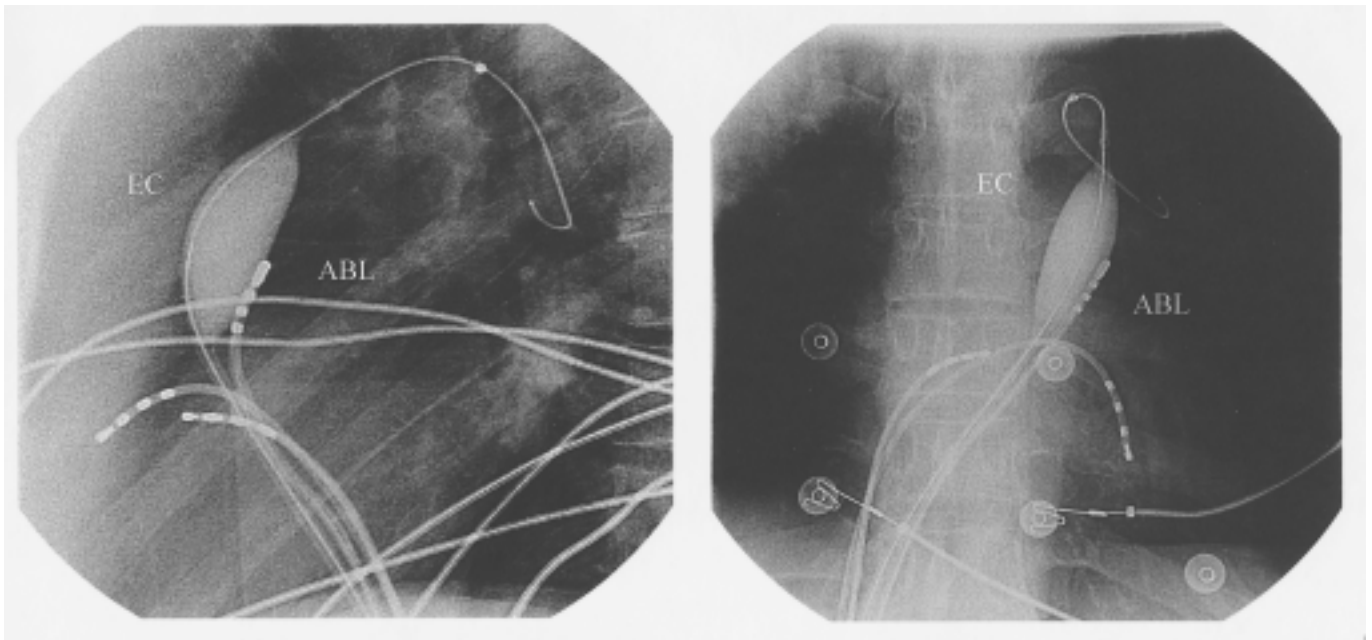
Right Panel. Anteroposterior view, and Left Panel. Lateral view. X-rays of the patient with ARVD and symptomatic ventricular ectopics with Ensight Catheter (EC) in-situ. ABL=ablation catheter.
